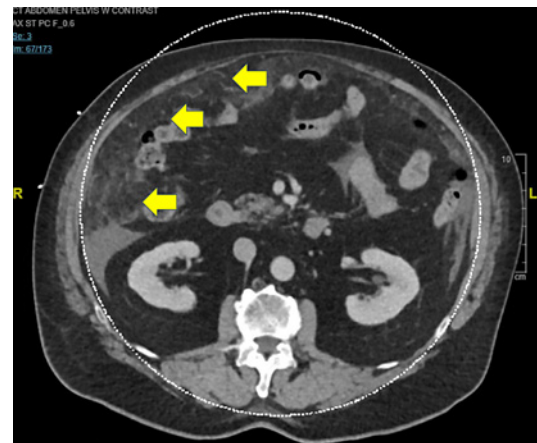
CT abdomen/pelvis showing omental stranding and edema (yellow arrows).
